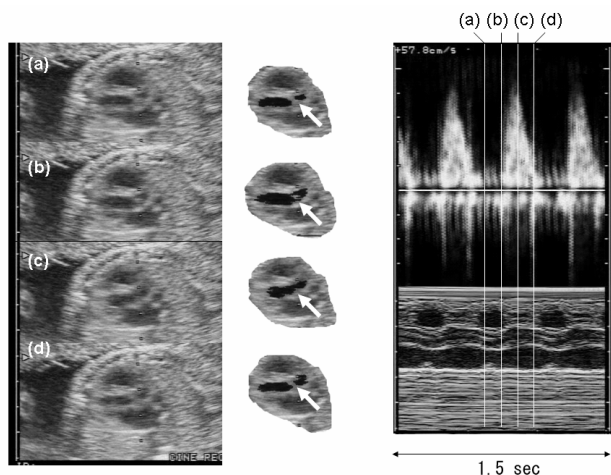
Left panels show B-mode views of a fetal aortic valve movements. The middle panels are the images extracted from B-mode views. White arrows show the aortic valve. Panel (a) shows the closing of the aortic valve, (b) shows the start of opening of the aortic valve, (c) shows that aortic valve is open and (d) shows that aortic valve is closed. The right panels show the Pulsed-wave Doppler signals during the opening and closing time of the aortic valve and its M-mode image at the same time phases.
